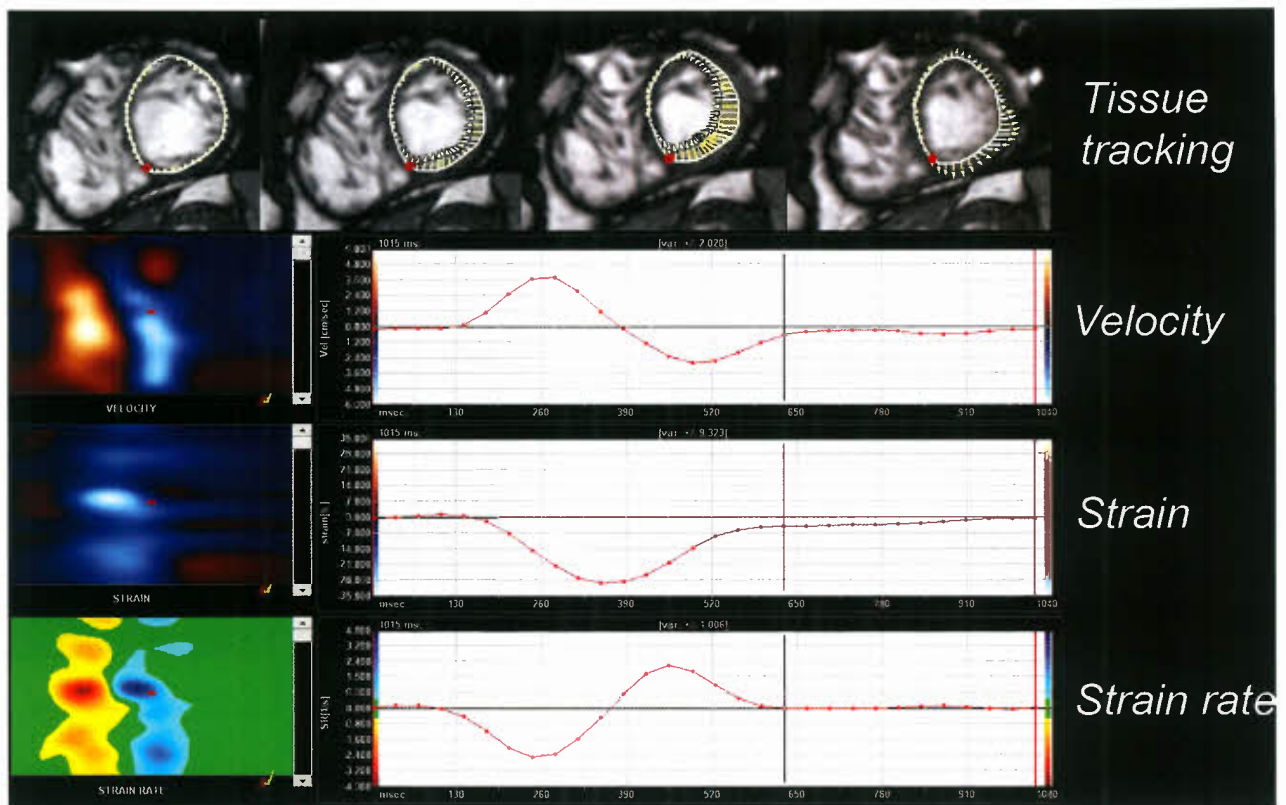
Tissue tracking CMR. The software tracks the motion of the left ventricular myocardium throughout the cardiac cycle on short-axis cine SSFP images (top panel), analogous to speckle tracking echocardiography. The tissue velocity, strain, and strain rate versus time are calculated (lower three panels).
